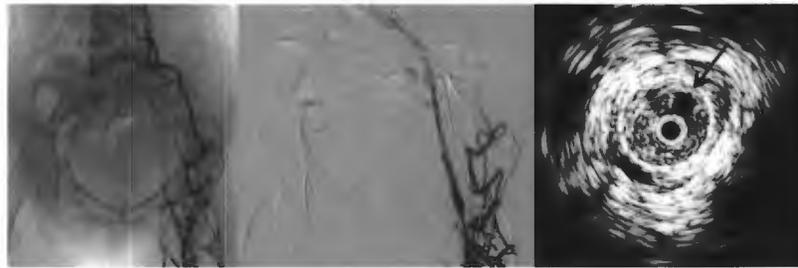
Stent thrombosis (left). Venogram shows restoration of axial flow (middle), but substantial residual thrombus remained (right). Intravascular ultrasound (IVUS) examination shows a small venographic channel (arrow) surrounded by thrombus.
